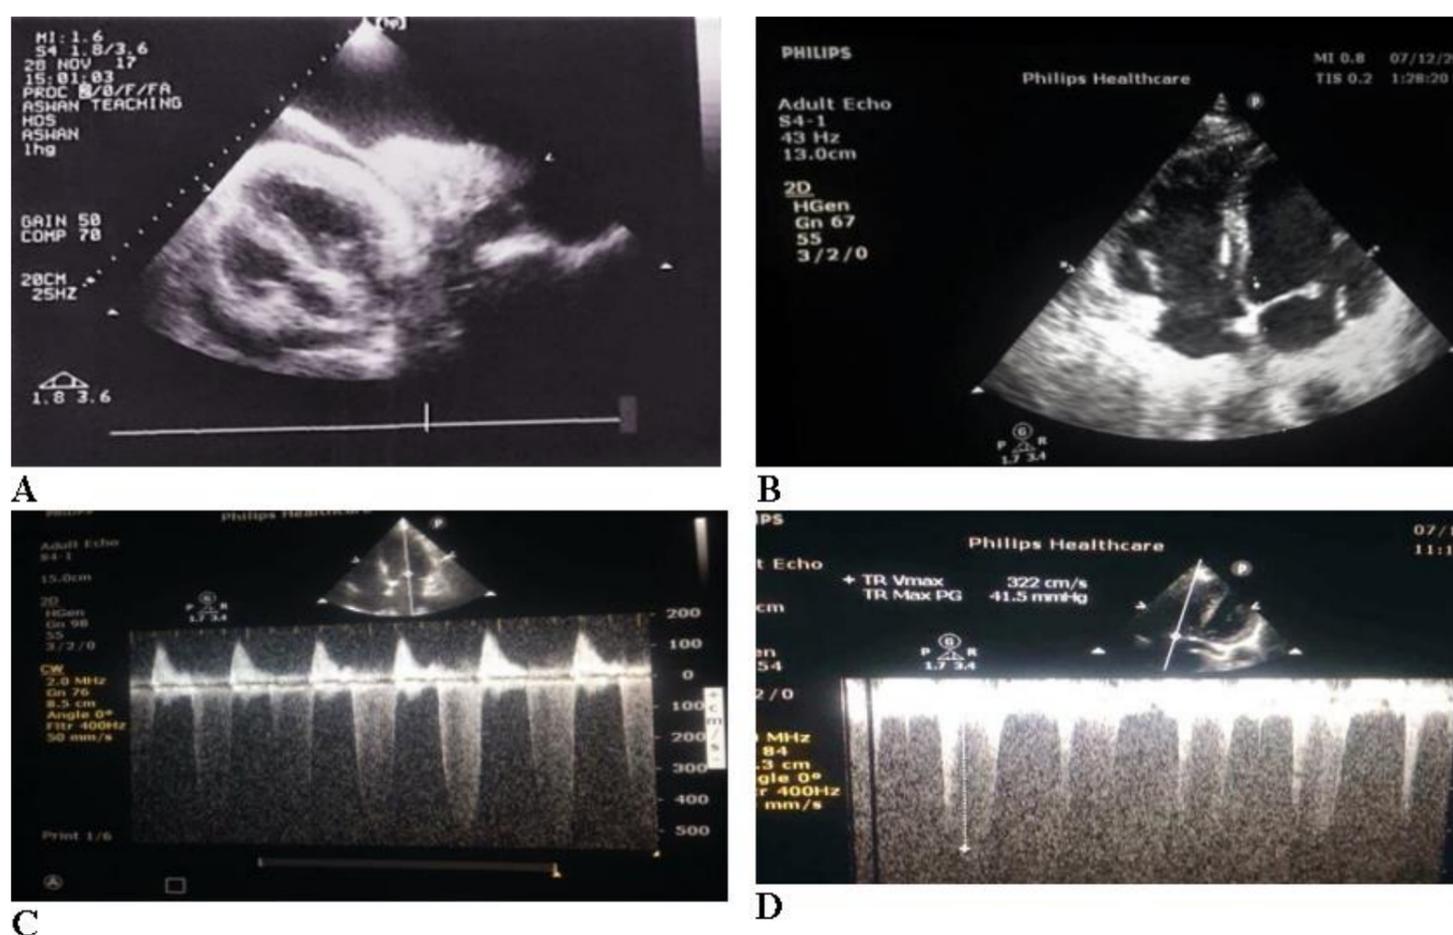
Examples of two-dimensional still-frames obtained from hand-held echocardiographic studies of four distinct patients. (A) Subcostal view obtained from a patient with SOB showed pericardial effusion. (B) Apical four chamber view obtained from a patient with SOB showed dilated right side and discover pulmonary hypertension (C) Apical four chamber view with CWD (continuous wave Doppler) obtained from a patient with SOB showed moderate to severe mitral regurgitation (D) Apical four chamber view with CWD (continuous wave Doppler) obtained from a patient with SOB shows moderate to severe tricuspid regurgitation with estimated PAP (pulmonary artery pressure) 51mmHg.
